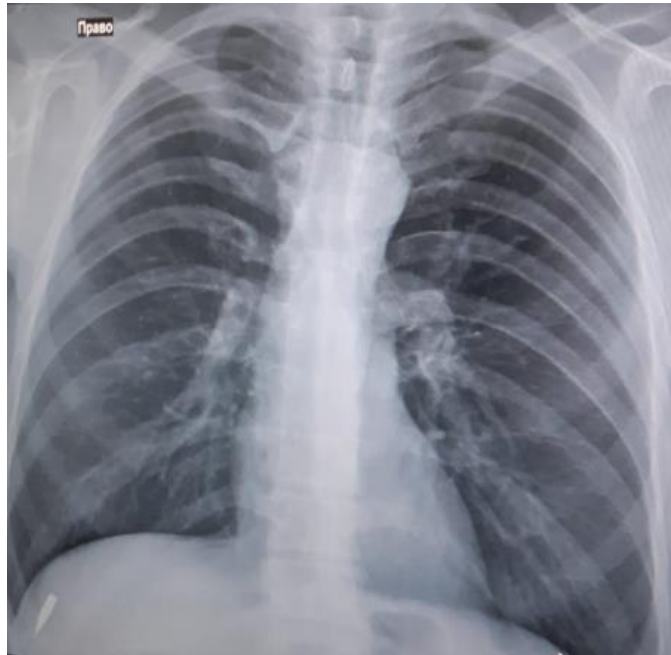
The same case. Anterior projection of the chest (X-ray). In the projection of the right lobe of the liver, a light linear formation is determined - a bullet.
